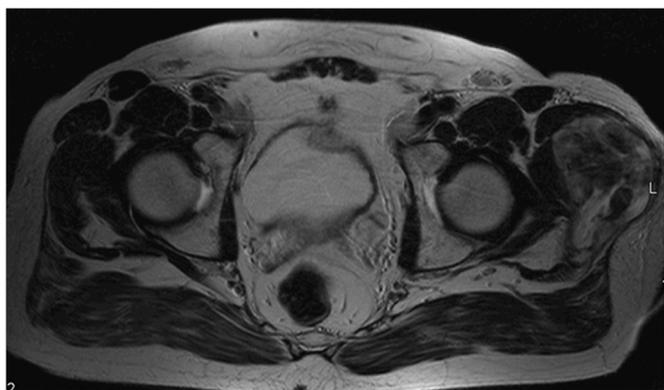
On the T2-weighted image the lesion is heterogenous hyperintense compared to the adjacent muscle.
